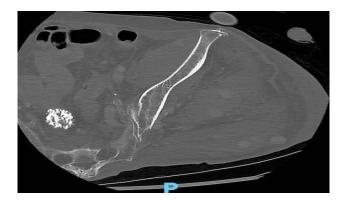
Axial cut of contrasted-CT hip showing multiple hyper-enhancing lesions in the left hip.
